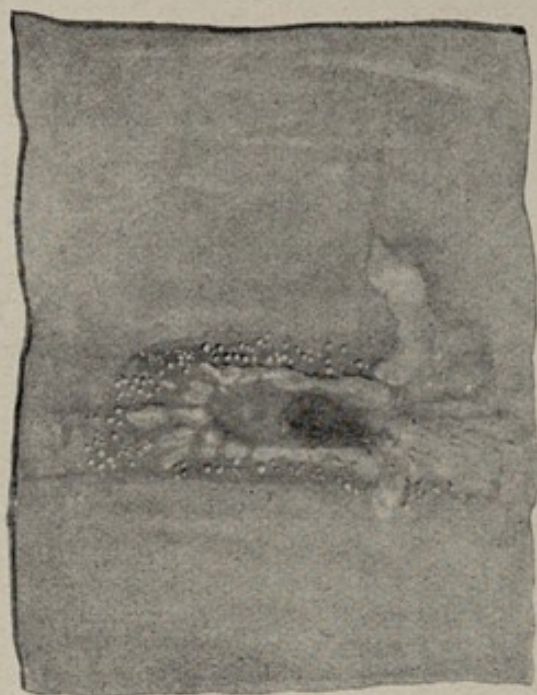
TUBERCULOUS ULCERATION OF SERUM, VIEWED FROM THE PERITONEAL ASPECT, SHOWING NUMEROUS SUBPERITONEAL TUBERCLES SURROUNDING THE FLOOR OF THE ULCER
